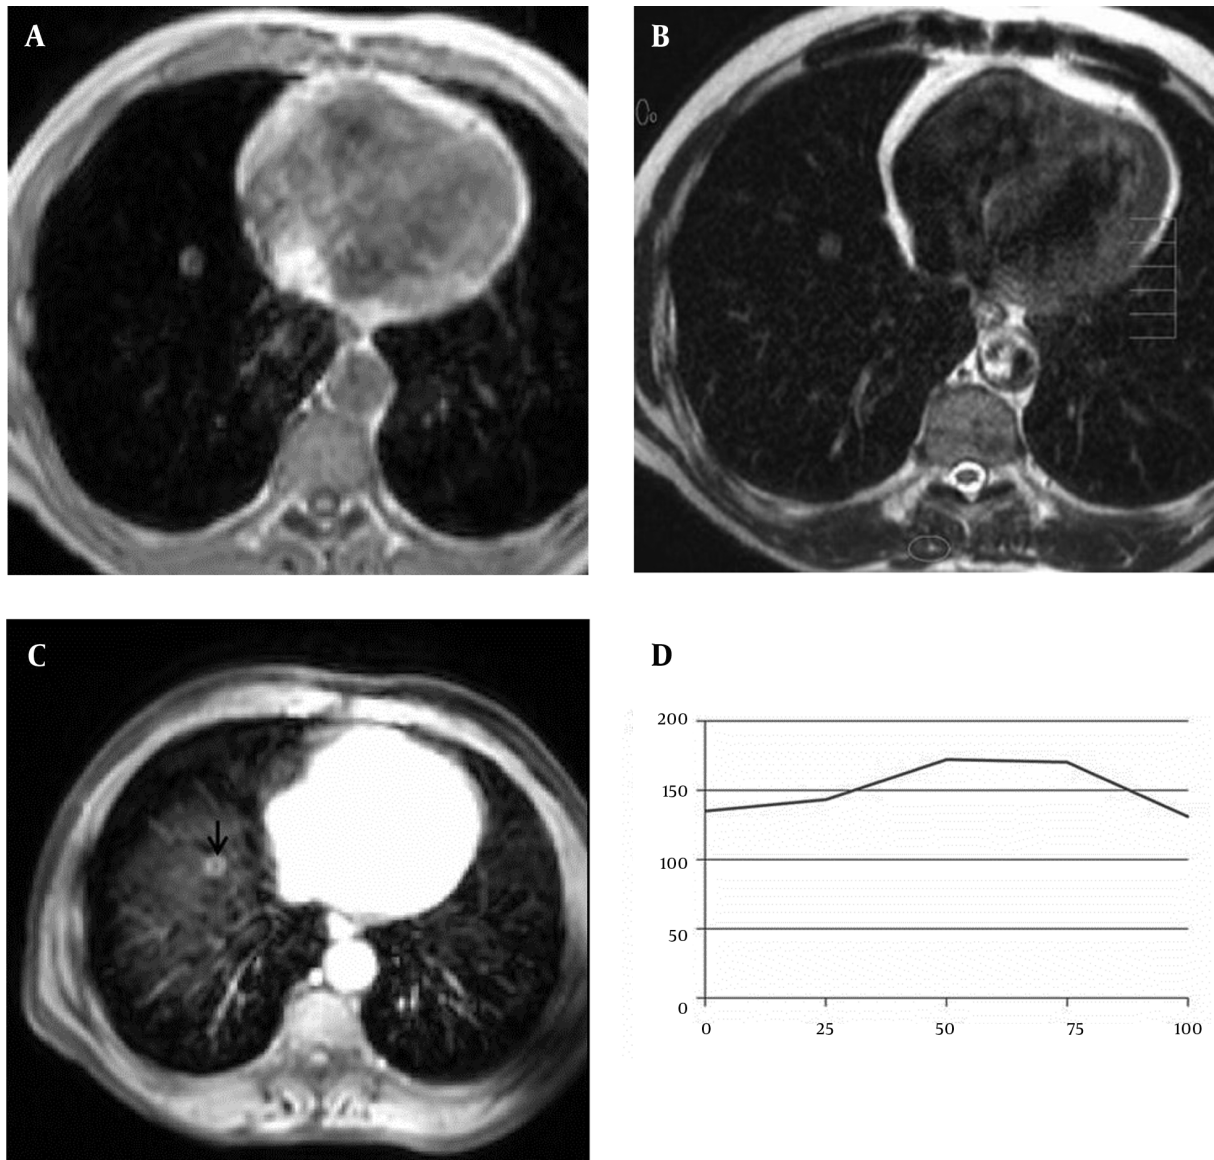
A 61-year-old man with benign solitary pulmonary nodule. A, Axial T1-weighted FFE and B, T2-weighted TSE MR images show a nodule in the right lower lobe of the lung. C, This nodule (arrow) shows peripheral ring-enhancement on the axial post contrast fat-suppressed T1-weighted image (5th minute). D, SI-time curve and quantitative interpretation of the curve obtained from the nodule. Maximum relative enhancement (27%) and wash-in rate (1.48 seconds) implied benign mass.
